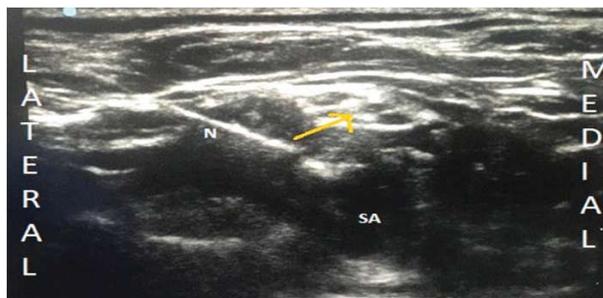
Transverse sonogram showing the needle targeting the neural cluster which is pushed up by the local anesthetic spread. N-Needle, SA-Subclavian Artery
